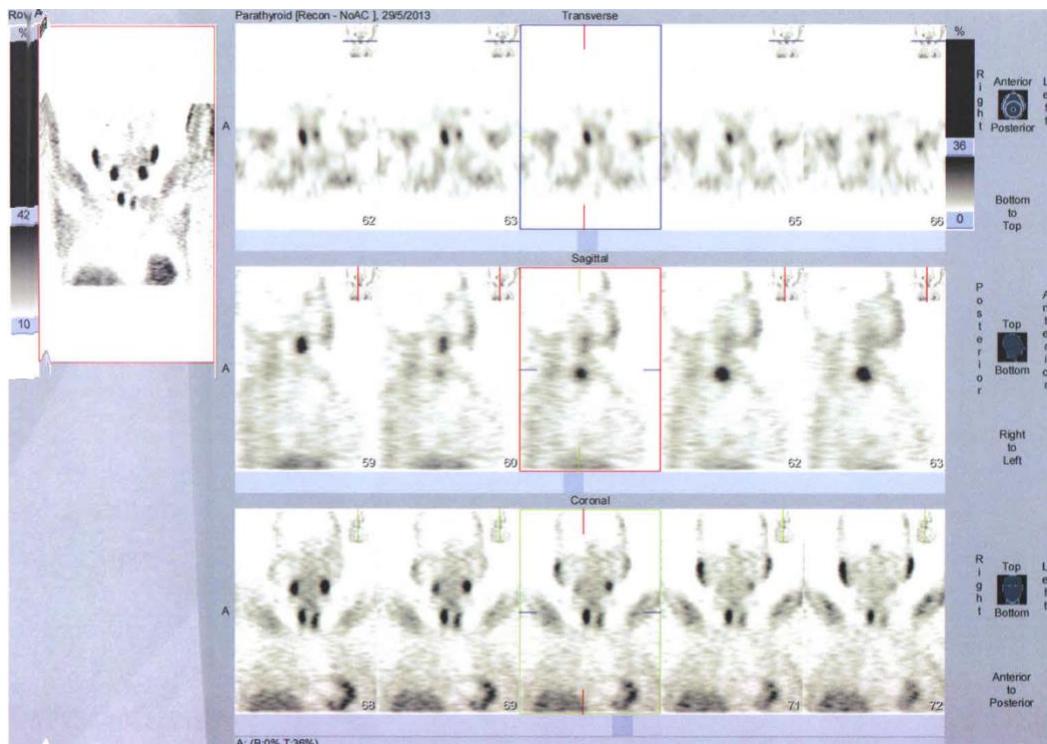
SPECT images – a hyperfixating zone located dorsally of the lower right lobe seen – adenoma of right parathyroid gland.
